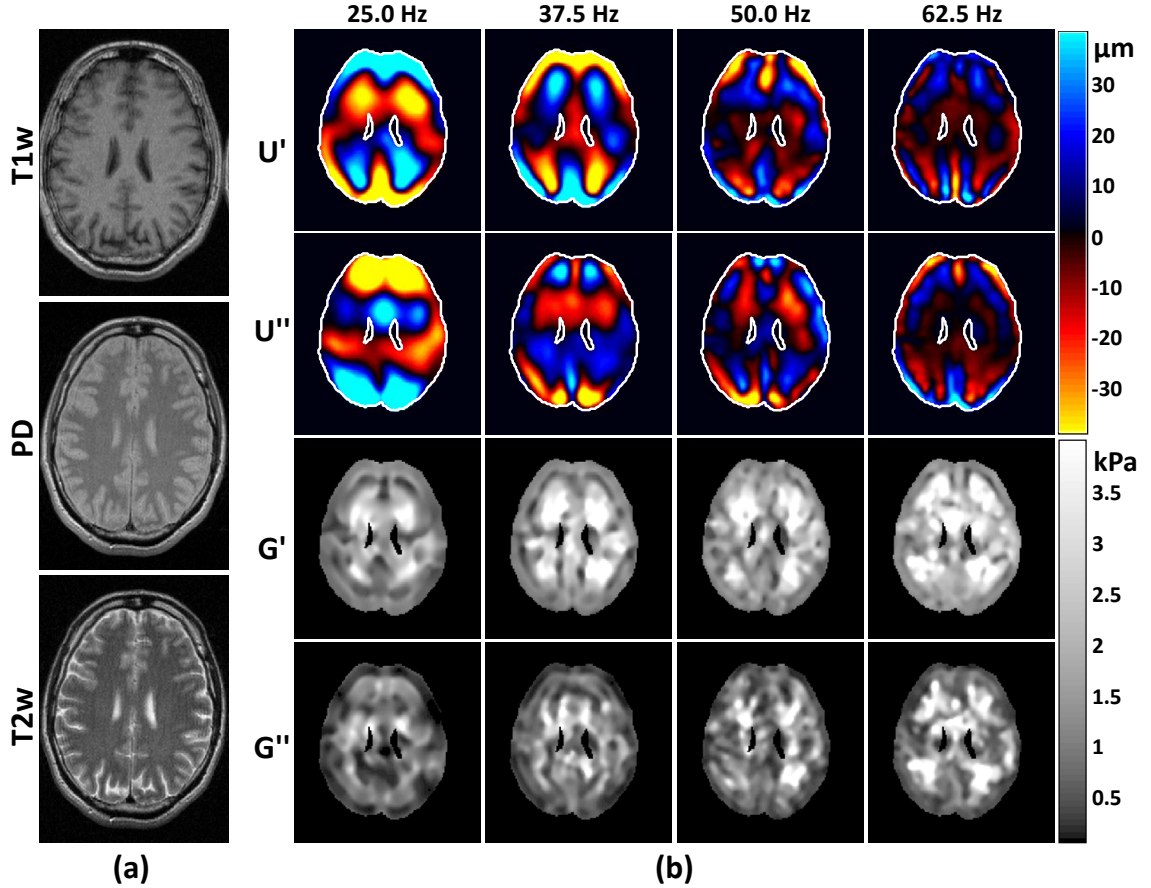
Magnetic resonance elastography (MRE) produces estimates of intracranial displacement fields observed in response to dynamic pressure loading of the skull. These can be inverted to estimate spatially varying mechanical properties of brain tissue. Example displacement fields shown here are obtained from a single-slice multifrequency MRE experiment. (a) Standard MR anatomical images: T1-weighted (T1w), proton density (PD), and T2-weighted (T2w) contrast. (b) Wave images and parameter fields. U' and U'' denote the real and imaginary parts of the first harmonic component $U(x, y, \omega)$ of the displacement field. The complex modulus images (G' and G'') denote the real and imaginary parts of the complex shear modulus $G^*(x, y, \omega)$. The driving frequencies are given above the columns. Reproduced from Reference [142].
